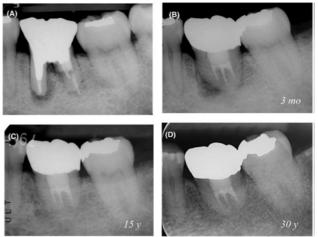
Patient 39 years old. (A) - X-ray before treatment; (B) - 3 months after autotransplantation and crown production; (C) - 15 years after follow-up; (D) - 30 years after surgery [18]
